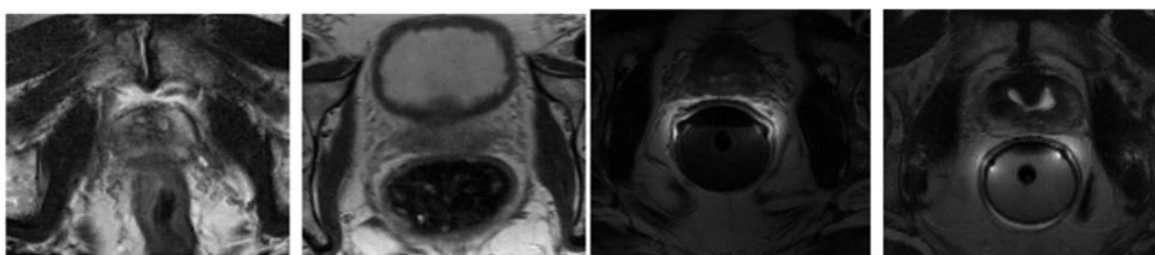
Examples of prostate 3D MR images from Promise12 data set
